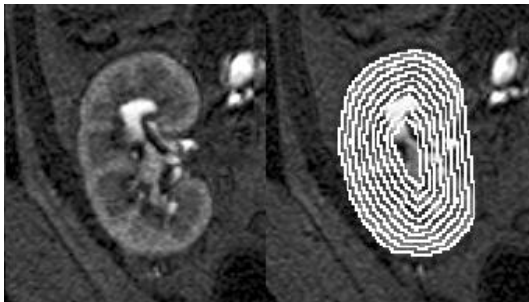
MR image of a kidney and the same image with the odd numbered onion rings displayed in it.
